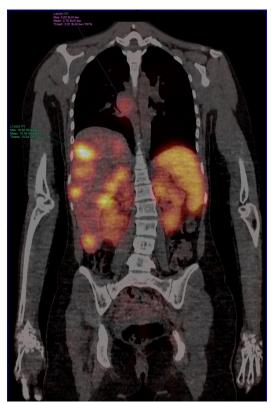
Coronal view of a fused xSPECT/CT image with measurements of one of the liver lesions as well as the hilar lymph node metastasis. Note the automated SUV measurements using syngo®.via. The tracer distribution, retention and elimination can be identified by comparing the two time points.
